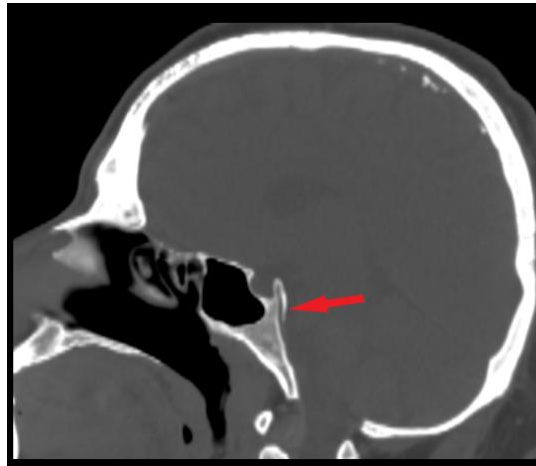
CT image sagittal view shows Canalis basalis medianus.
